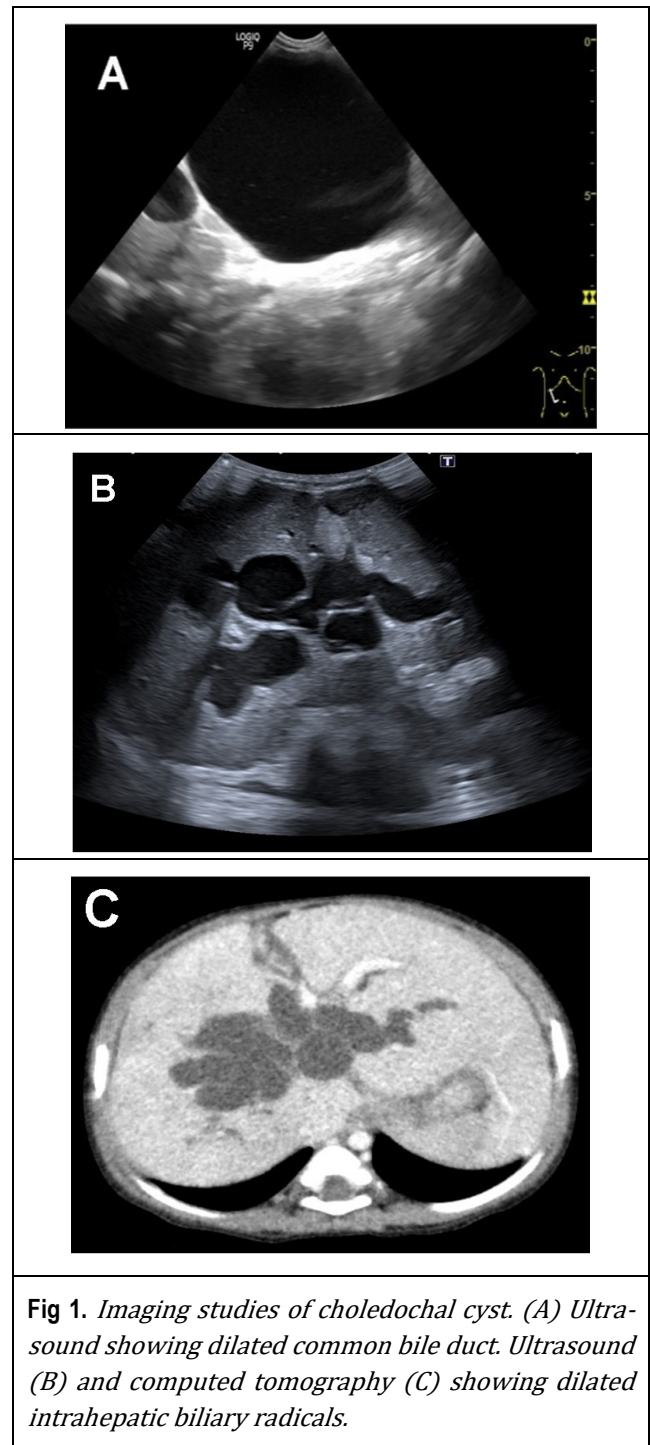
Imaging studies of choledochal cyst. (A) Ultrasound showing dilated common bile duct. Ultrasound (B) and computed tomography (C) showing dilated intrahepatic biliary radicals.*
